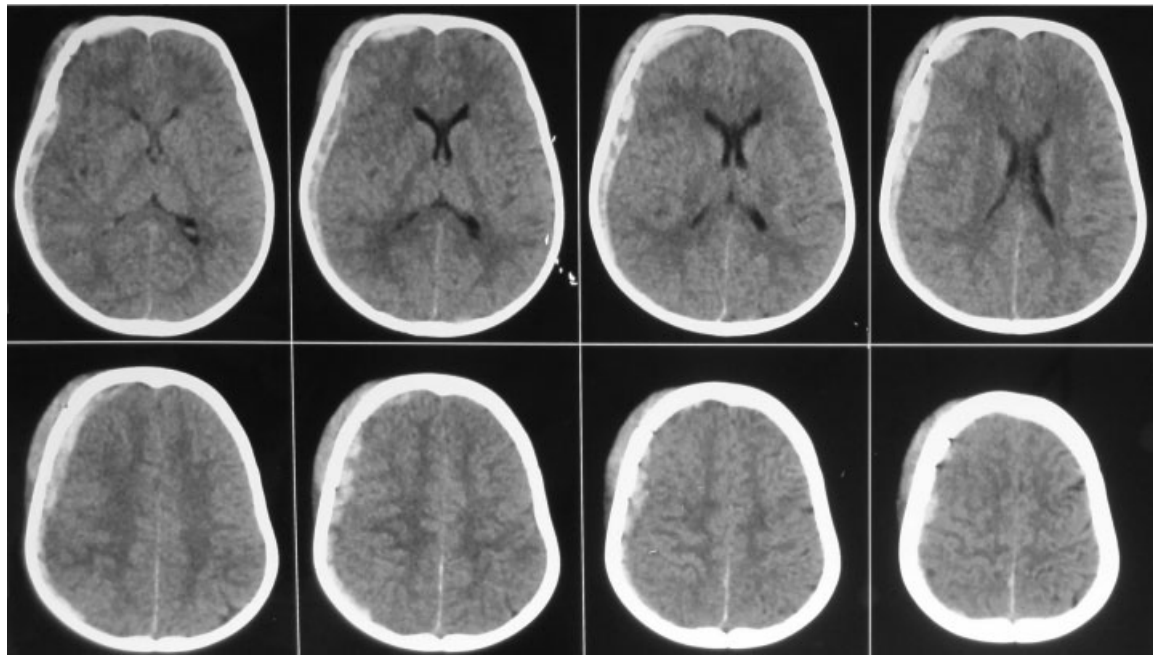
CT brain plain at admission, 2 hours after trauma. CT, computed tomography.
